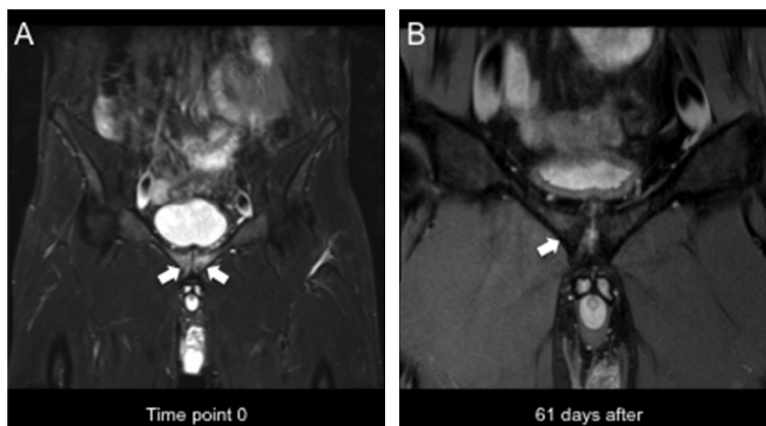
Case of a bone marrow oedema in os pubis. Twenty-three-years old soccer player reported at first visit about recurrent pubic pain since more than five months preventing him from full training. No trauma was detectable. MRI shows an intense BMO of the os pubis, accentuated on the right side, in the frontal plane (arrows). Follow-up imaging after high dose vitamin D and bisphosphonate treatment reveals a significant decrease of the oedema correlative with a significant decrease of pain (right side still visible marked by with an arrow). The RTC was recorded after 89 days.
